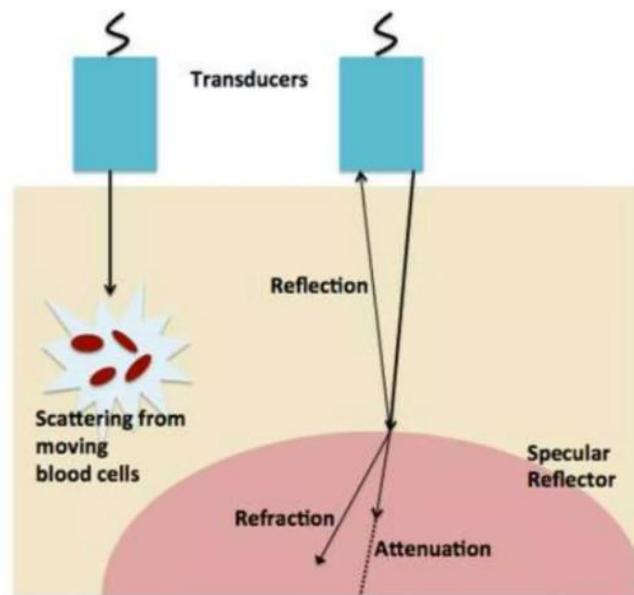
Ultrasound interaction with matter
